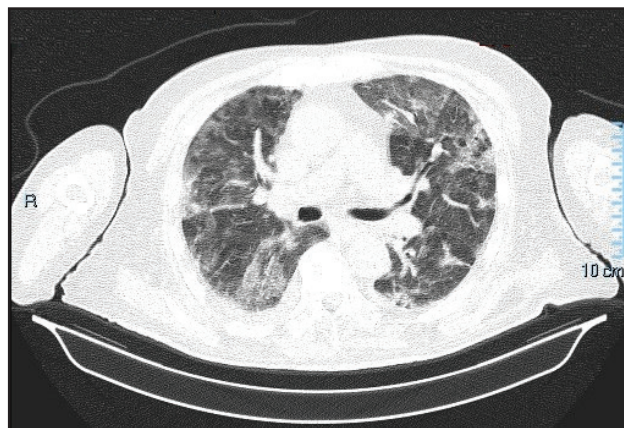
The native CT scan of the thorax in the 10th day of hospitalization at IDHC, indicates: bilateral pulmonary condensations which are suggestive for SARS-CoV-2 lesions in various stadia of evolution, with severity score 20 and severe damage; free bilateral pleuresia in small quantity.
